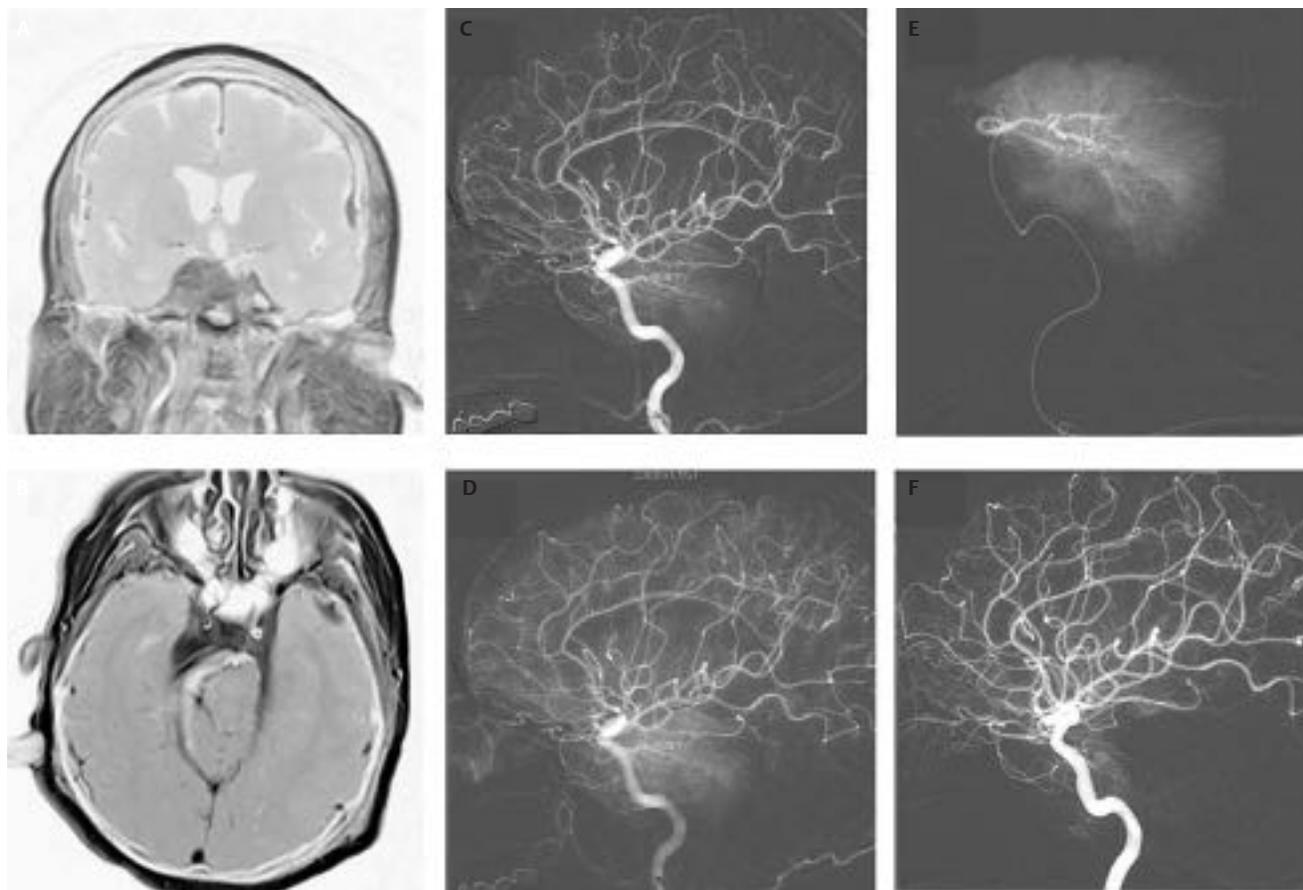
Suprasellar meningioma. (A) Coronal and (B) axial magnetic resonance imaging demonstrating a homogeneously enhancing mass that encases the bilateral internal carotid arteries. Lateral right internal carotid artery angiograms in the (C) arterial and (D) capillary phases demonstrating a suprasellar tumor blush supplied by enlarged dural branches of the meningohypophyseal trunk. (E) Superselective angiogram of the meningohypophyseal trunk. (F) A significant decrease in the size and intensity of the tumor blush following polyvinyl alcohol and coil embolization of the meningohypophyseal branch supplying the tumor.
